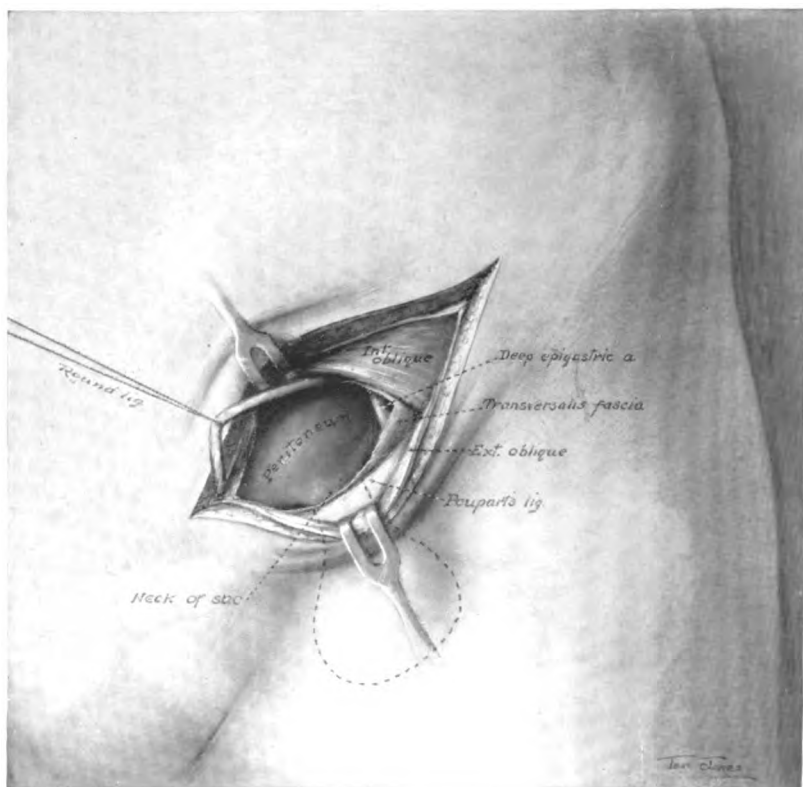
SKIN, SUBCUTANEOUS TISSUE, EXTERNAL OBLIQUE, AND TRANSVERSALIS FASCIA HAVE BEEN INCISED AND THE UPPER AND LOWER FLAPS RETRACTED UPWARDS AND DOWNWARDS, RESPECTIVELY. (*Seelig.*)
